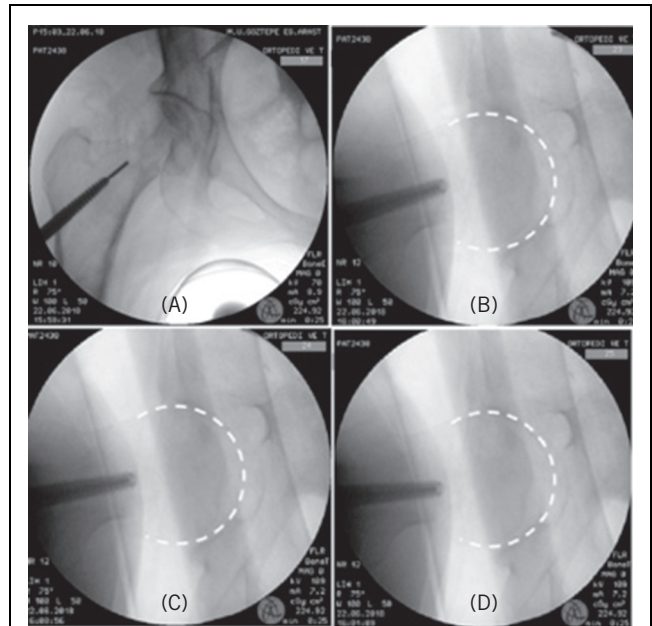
Fluoroscopy during reduction: The femoral head generally falls to the posteroinferior part of the femur after a neck fracture. Under anteroposterior and lateral x-ray guidance, the reduction tool is advanced from the lateral femoral cortex to the fracture line (A). Lateral traction is applied to separate the femur from the head and the femur is then gradually rotated internally (B–D).
